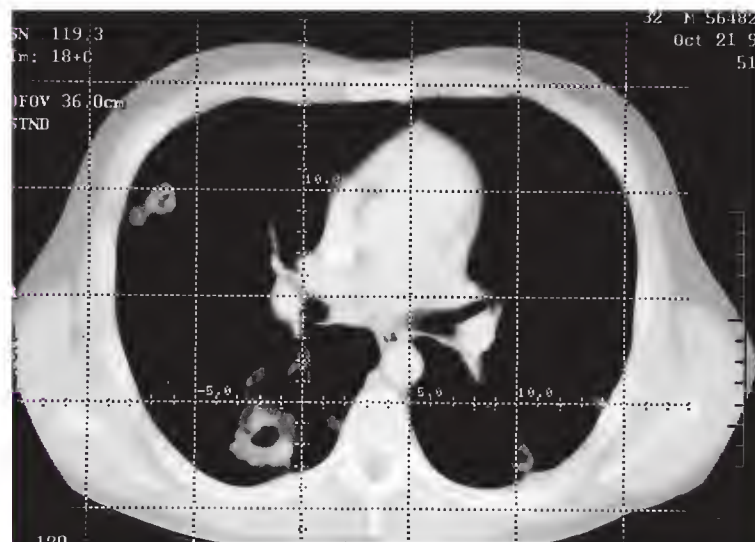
Computed tomographic image of the chest for a patient with granulomatosis with polyangiitis. Multiple bilateral pulmonary nodules can be seen, many of which have cavitated.
